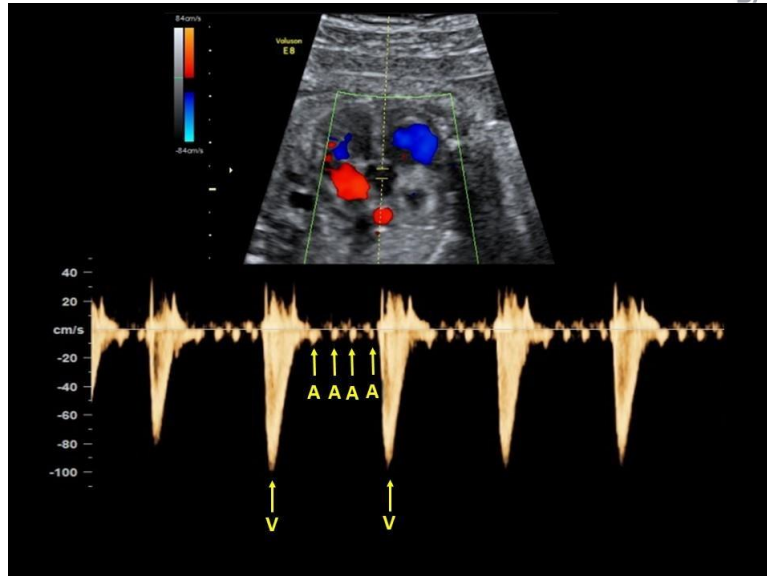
Atrial flutter. Mitral and aortic pulsed Doppler showing how the atrial rate (A) is much higher than the ventricular rate (V).
